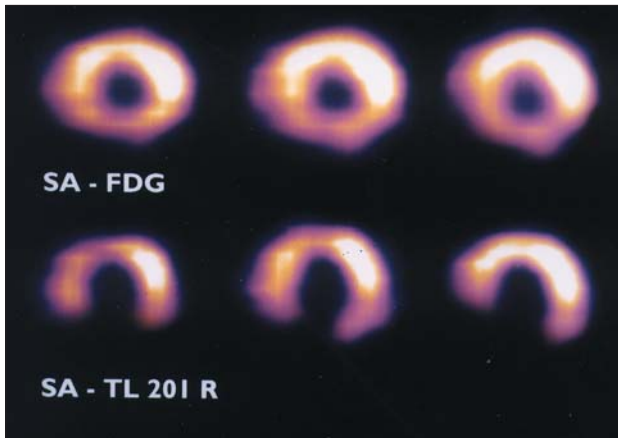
Two series of short-axis slices of a patient with a perfusion-FDG mismatch; in the inferior wall, perfusion (assessed by resting thallium-201, lower series) is absent, whereas FDG uptake (upper series) is relatively preserved. (Reproduced from reference 54 with permission.)
